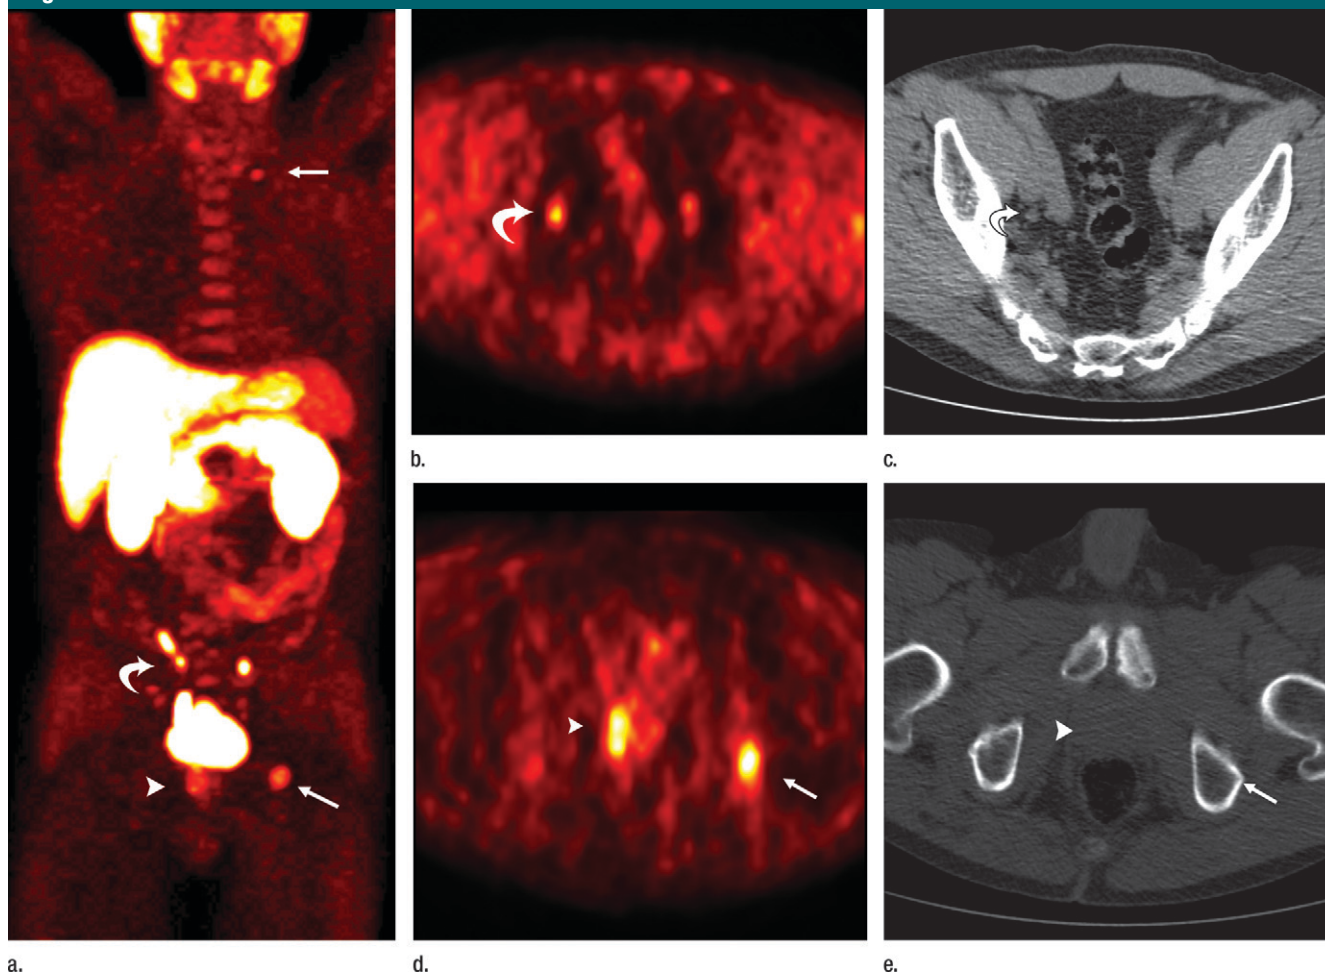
Images obtained in a 71-year-old patient with prostate cancer that was upstaged at FCH PET (Gleason score, seven; PSA level, 4.7 ng/mL [4.7 $\mu\text{g/L}$]). All abnormal lesions were confirmed to be malignant on the FCH PET/CT images obtained 9 months after primary staging. (a) Maximum intensity projection FCH PET image shows positive FCH uptake in the prostate (arrowhead), a right pelvic LN (curved arrow), and two bone metastases (straight arrows). (b) FCH PET image shows positive FCH uptake in a right external iliac LN metastasis (curved arrow). (c) The positive right pelvic LN seems to be unremarkable on the CT portion of an FCH PET/CT image, with a 9-mm short-axis diameter (arrow). (d) FCH PET image shows positive FCH uptake in the right lobe of the prostate (arrowhead) and in the left acetabulum (arrow). (e) CT portion of an FCH PET/CT image shows no substantial morphologic change in the detected lesion in the left acetabulum (arrow), probably because of early bone marrow infiltration. The lesion detected at FCH PET was localized in the right prostate lobe (arrowhead).
